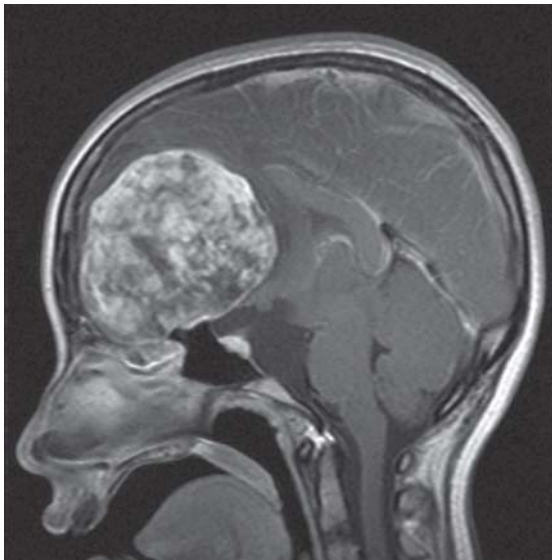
A large frontal skull base mass with heterogeneous enhancement on contrast enhanced T1-weighted images
